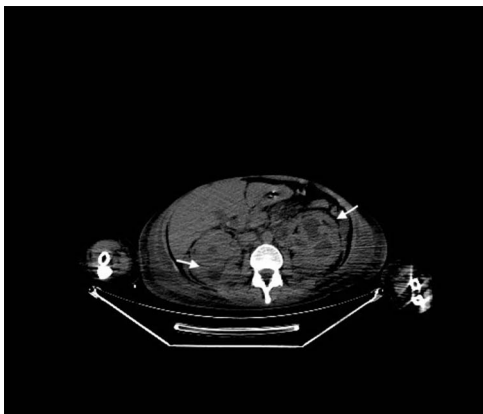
Axial abdomen computed tomography-scan image showing bilateral hydronephrosis and bilateral infiltration of perirenal tissue (white arrows).
